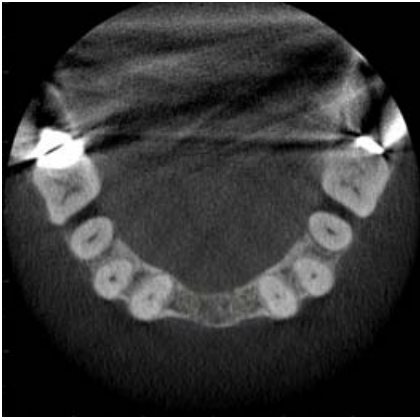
Axial CBCT image at a coronal and apical position
